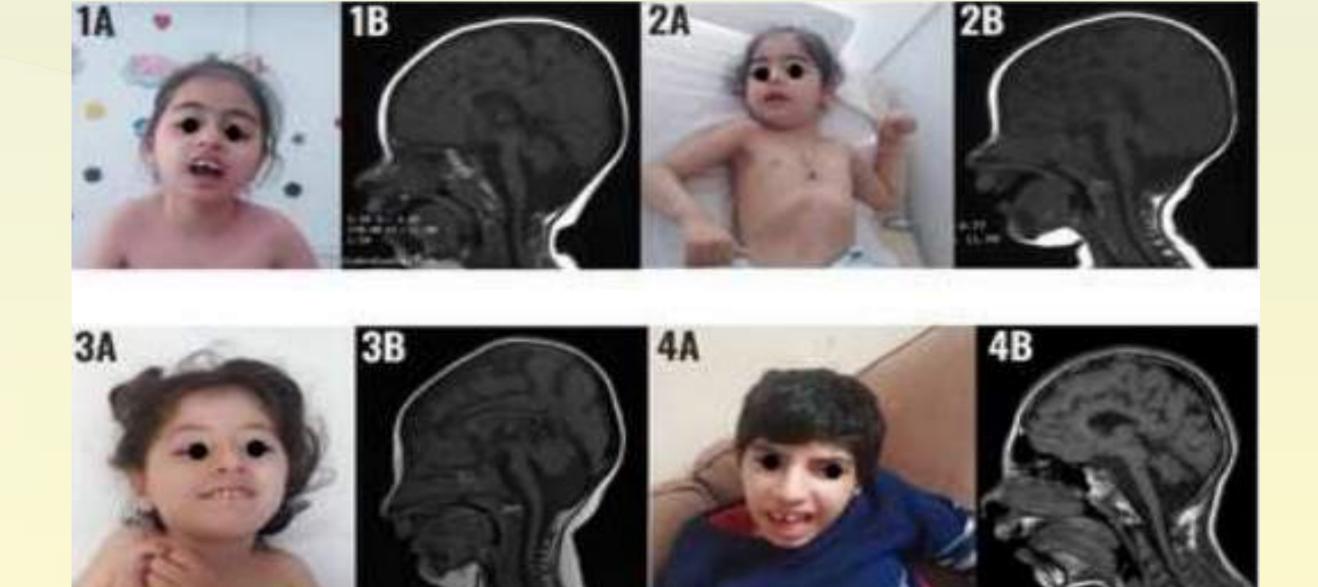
Dysmorphological features and MRI findings of our patients: Figure 1A image 1A and 1B: case 1, image 2A and 2B: case 2, image 3A and 3B: case 3, image 4A and 4B: case 4
